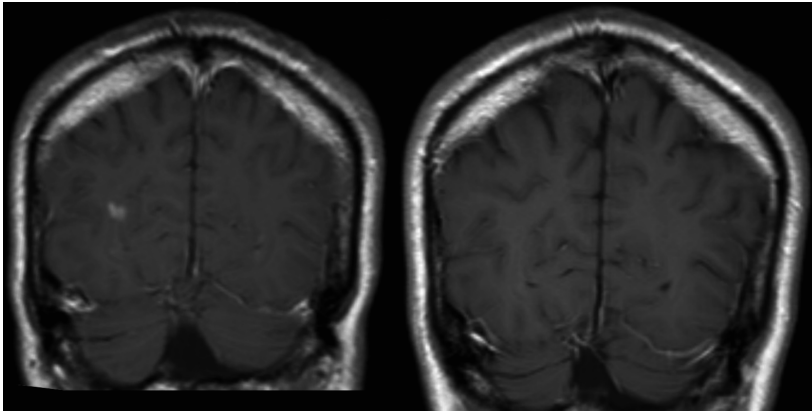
Brain MRI before and after treatment (patient 2)
